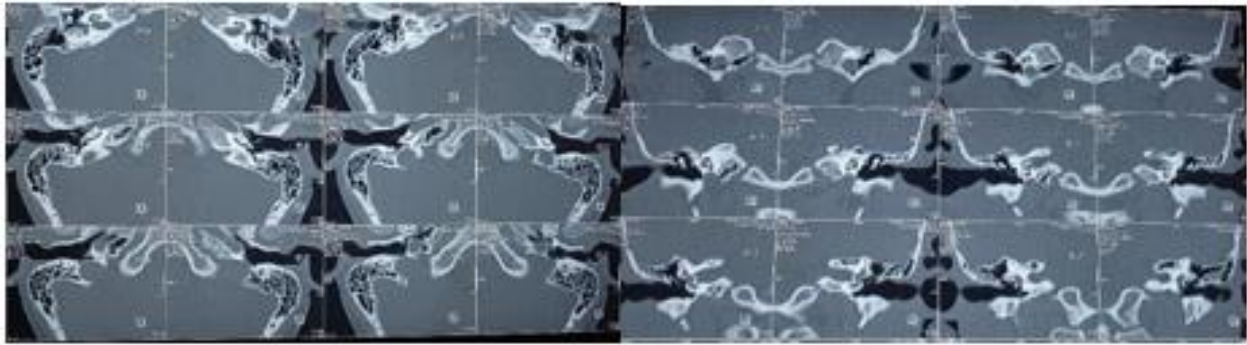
Image of Temporal bone CT
